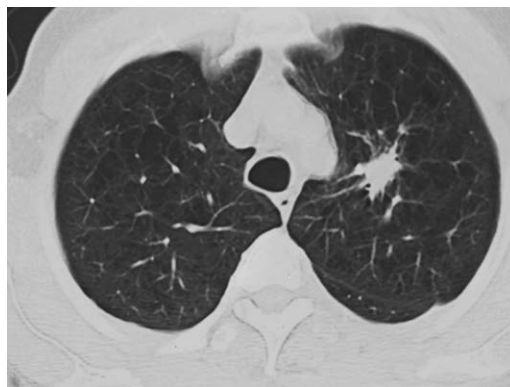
Chest CT with lung windows shows a spiculated nodule in the left upper lobe centrally. Bronchoscopy revealed granulomas and fungal organisms consistent with blastomycosis. This lesion resolved over several months.
